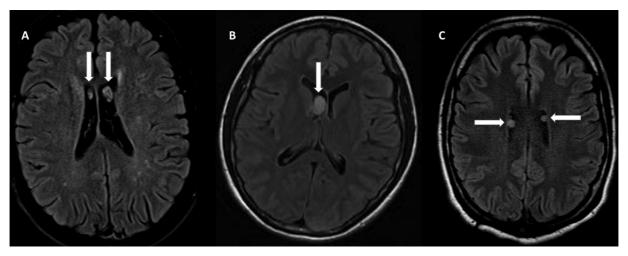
Axial FLAIR scan with CSF pulsation artifact and its differential diagnosis. CSF flow artifact on the lateral ventricles (arrows; A), mimicking subependymal nodules (B) or ring-shaped lateral ventricular nodules (C). B - Patient with tuberous sclerosis and subependymal giant cell astrocytoma (SEGA; arrow). Size of the lesion, postcontrast enhancement and growth suggest that a subependymal nodule in a patient with tuberous sclerosis might have developed a subjacent SEGA.
